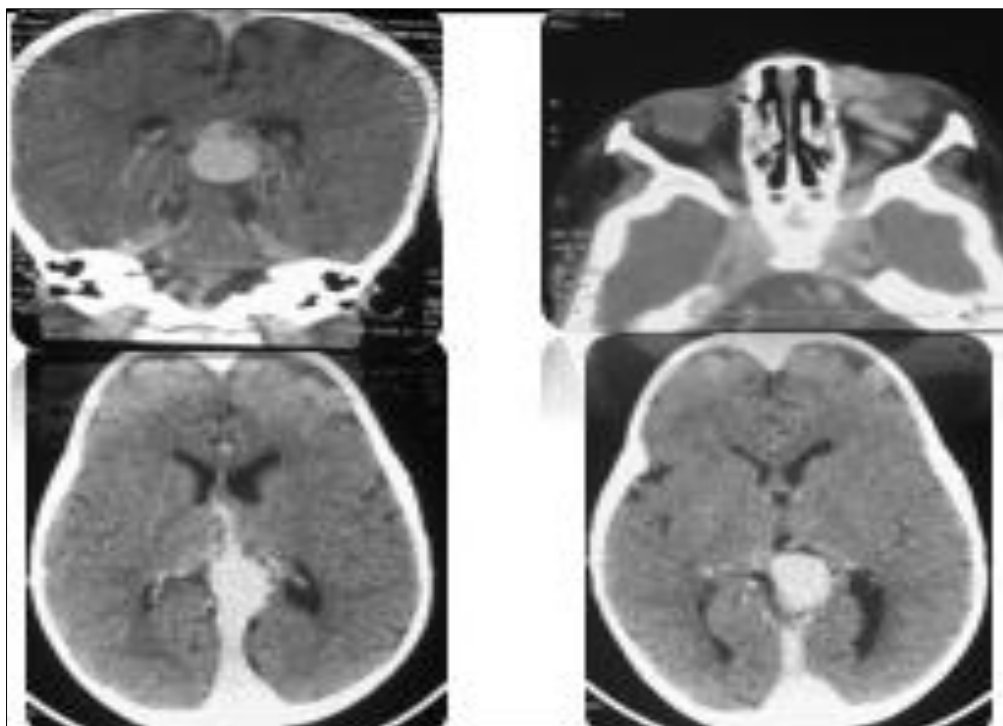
Brain CT in axial section and injected reconstructions. Cerebral vessel ectasia with aneurysm of Galen's vein
